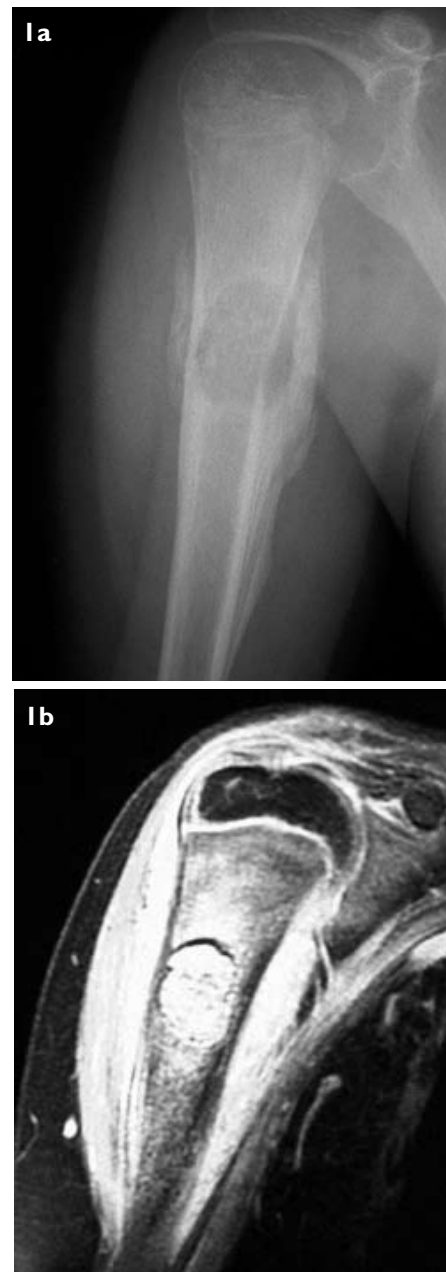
(a) AP radiograph of the right proximal humerus shows a large osteolytic lesion in upper humeral diaphysis with prominent periosteal reaction. There is cortical destruction of the medial cortex and a pathological fracture. (b) Enhanced fat-saturated coronal T1-weighted MR image shows the added information of a markedly-enhancing lesion in the diaphysis with extensive bony and soft tissue oedema.
